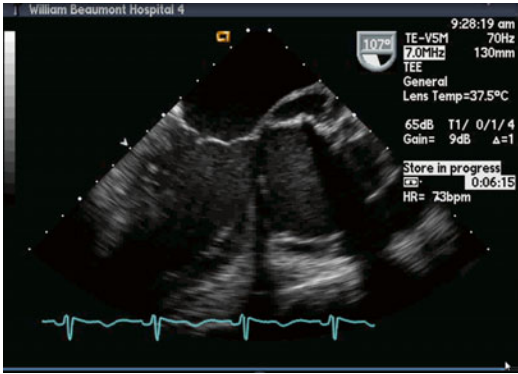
Trans-esophageal echocardiography image of the mechanical aortic valve dehiscence
